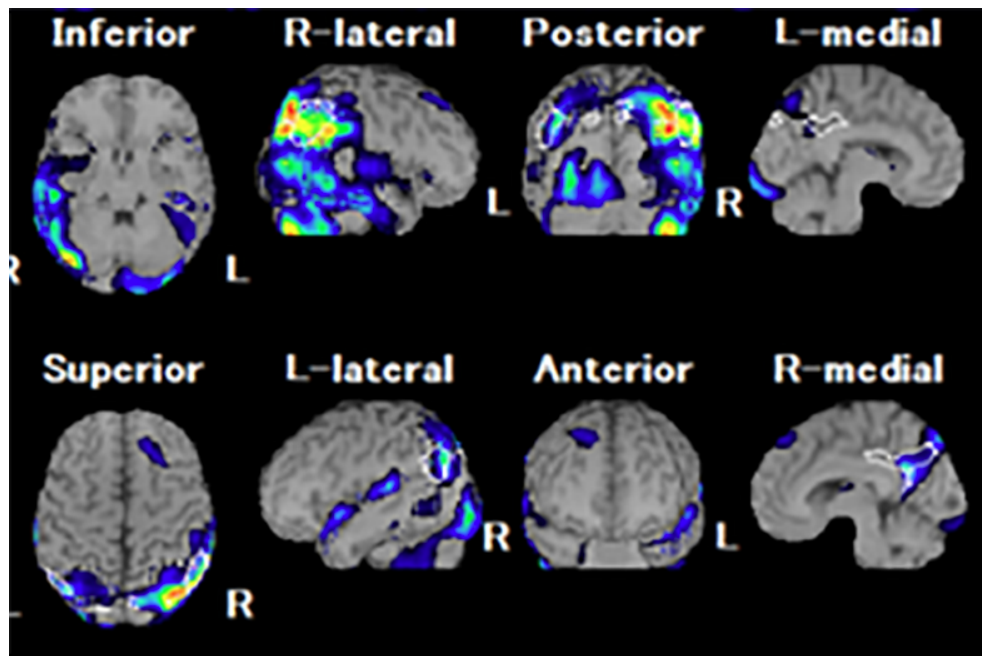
N-isopropyl-p-[^{123}I] iodoamphetamine single-photon emission computed tomography (SPECT) data analyzed with an easy Z-score imaging system found hypoperfusion in the right-predominant bilateral temporoparietal region and in the bilateral precuneus/posterior cingulate cortex.
